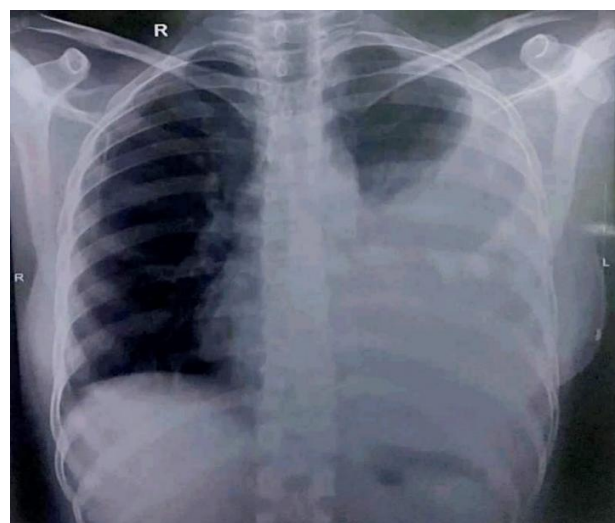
Chest X-ray posteroanterior view of AB.
